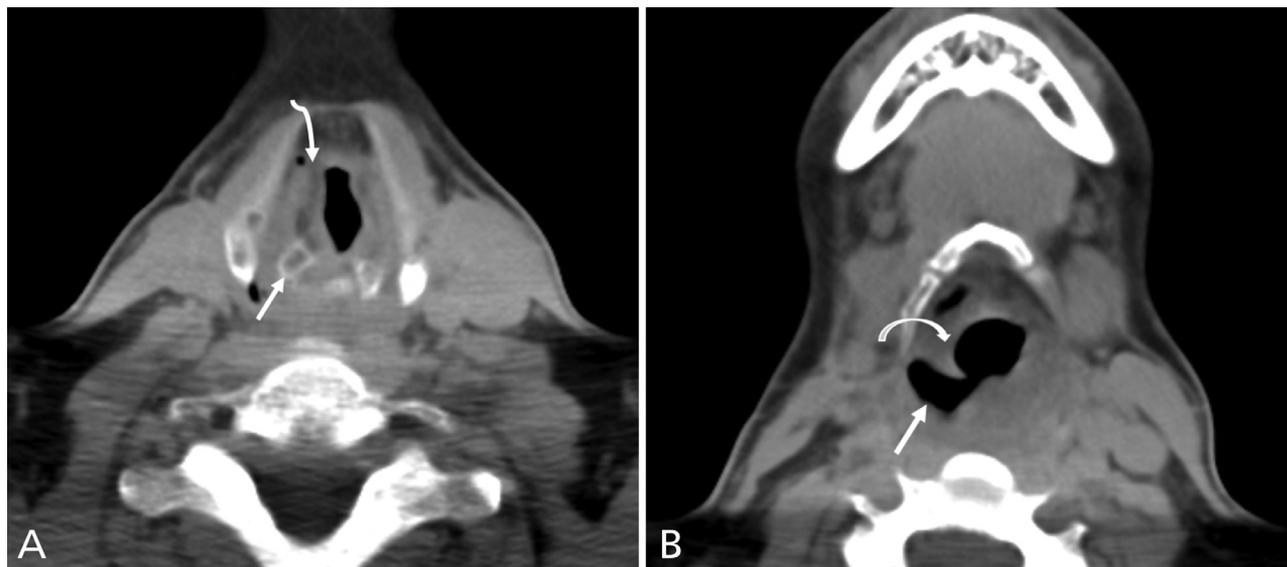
Right vocal cord paralysis. (A) Axial noncontrast CT at the level of the arytenoid cartilages demonstrates anteromedial deviation of the right arytenoid cartilage (arrow) and relative atrophy of the thyroarytenoid muscle (curved arrow). (B) Axial noncontrast CT at the level of the hyoid bone demonstrates enlarged right pyriform sinus (arrow) with medialization and thickening of the right aryepiglottic fold (curved arrow).
